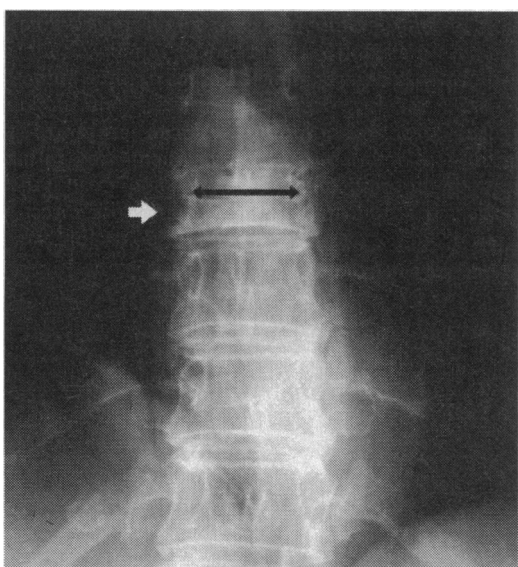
Anteroposterior radiograph showing a crush fracture of T8 with widening of the interpedicular space.
